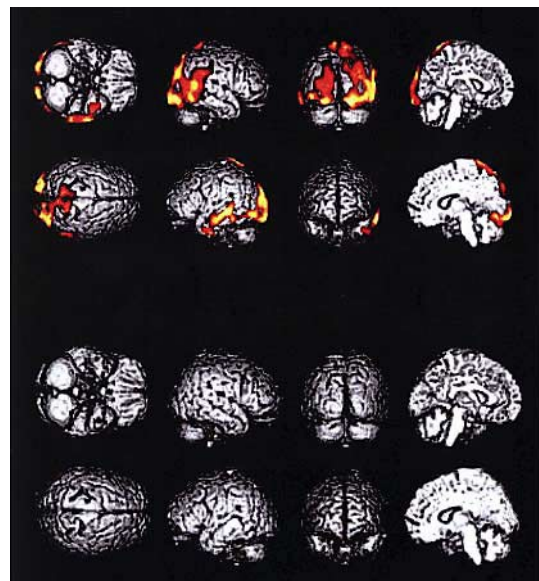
Forty-five-year-old woman. Improved case. Serum T3, T4, and TSH (0.4 ng/ml, 1.8 μ g/dl, 120 μ IU/ml) changed to the normal range (1.1 ng/ml, 10.3 μ g/dl, 0.1 μ IU/ml) after thyroid hormone administration. On the 99m Tc-HMPAO SPECT using SPM analysis by the Jack-knife test, there was significantly decreased rCBF in the bilateral posterior lobe, posterior lobe, and bilateral superior temporal lobe in the hypothyroidic condition (*upper*). These decreased rCBF area improved after thyroid hormone therapy (*lower*).
